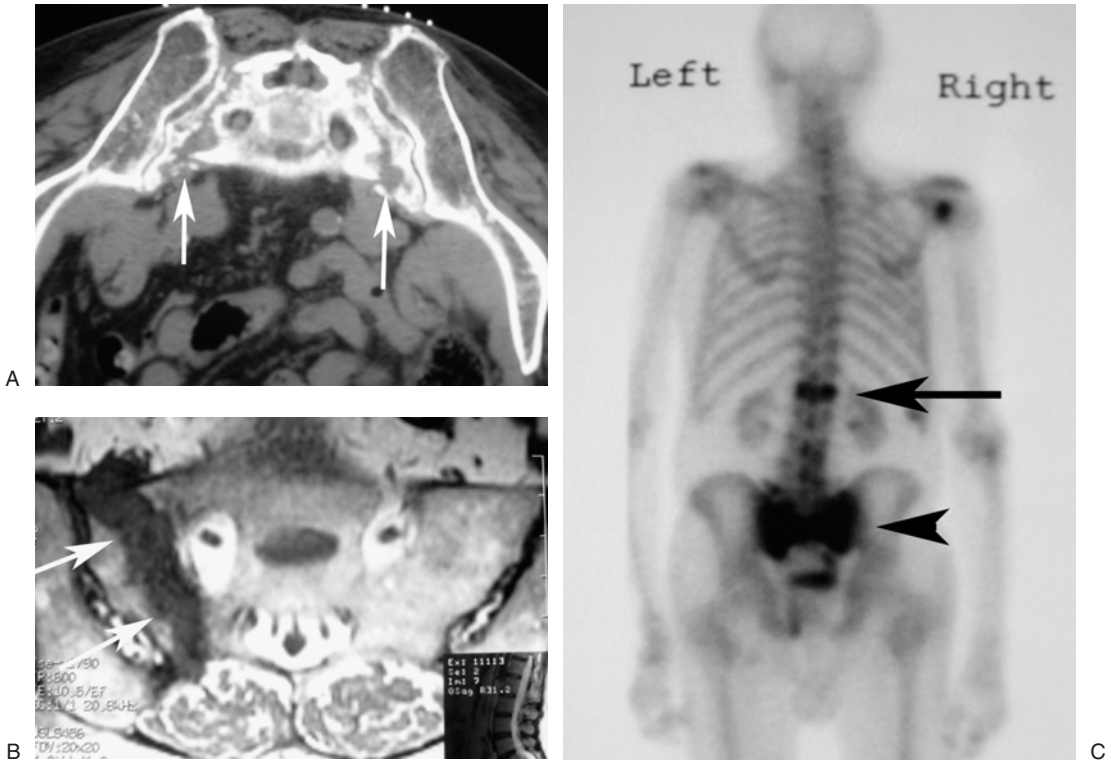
(A) Axial CT demonstrates bilateral sacral wing fractures (white arrows). (B) Coronal T1 MR image shows a unilateral sacral wing fracture (white arrows). The dark signal in the fracture is consistent with marrow edema. (C) A bone scan demonstrates a sacral insufficiency fracture (black arrowhead) associated with a vertebral compression fracture (black arrow).
